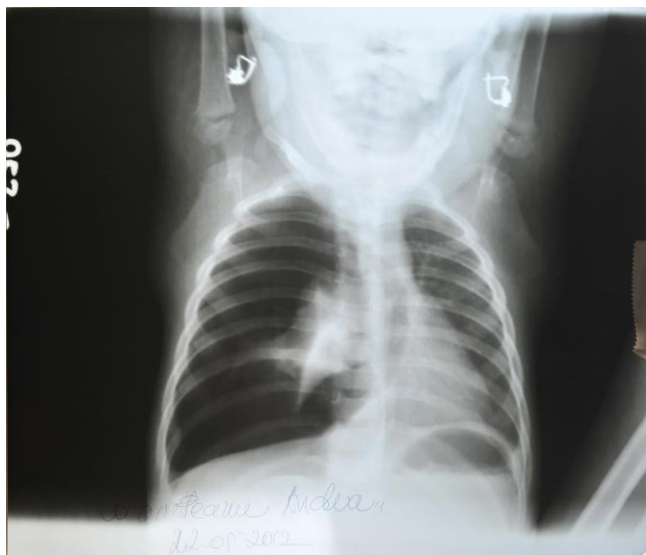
Emergency chest x-ray shows total right pneumothorax.
